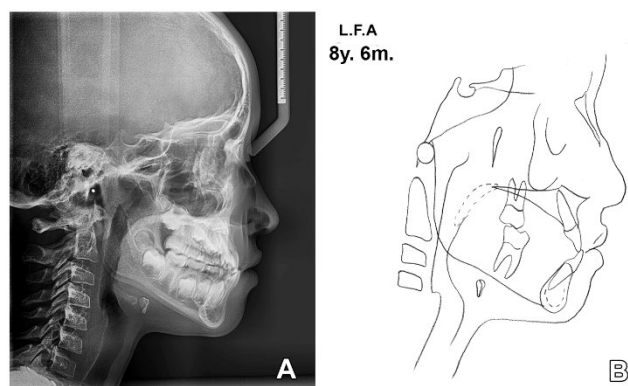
Pretreatment cephalometric records. A: Lateral cephalometric radiograph demonstrating skeletal Class III relationship due to maxillary retrusion; B: Cephalometric tracing highlighting ANB discrepancy and vertical growth pattern
